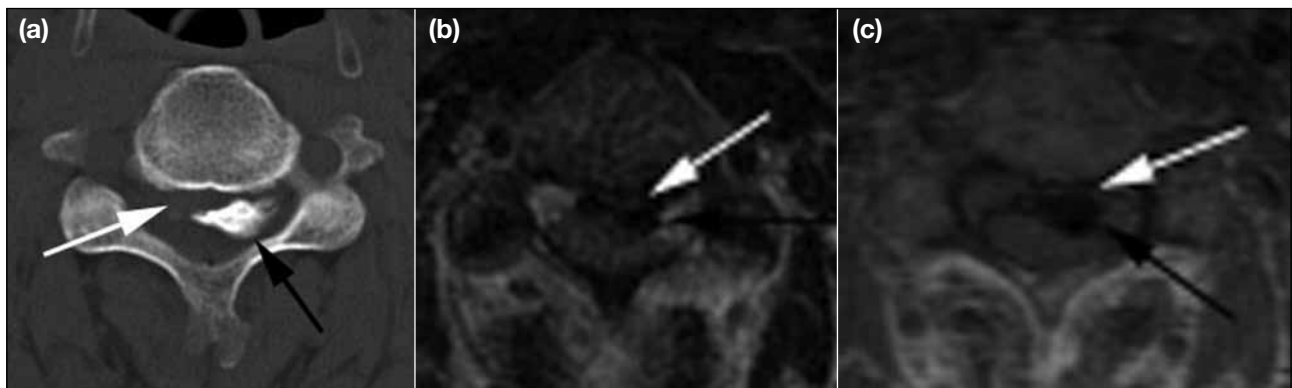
A 57-year-old male positively identified on initial magnetic resonance with confirmatory computed tomography (CT). (a) Axial CT, (b) T2-weighted and (c) T1-weighted axial images at the same level shows thickened and continuous ossification of the posterior longitudinal ligament (black arrows) with characteristic sharp and thin radiolucent line or intermediate signal separating the ossified posterior longitudinal ligament from the posterior vertebral margin (white arrows).
